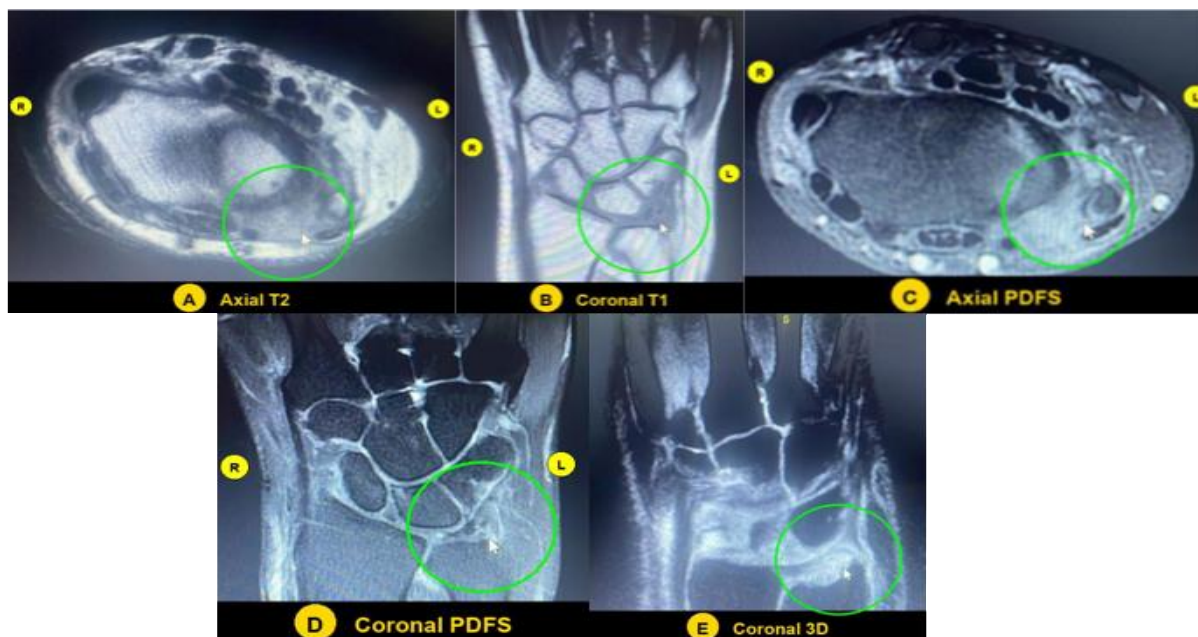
Patient came with complaints of wrist joint pain, decreased range of motion (ROM), and tenderness. Case shows MRI of the left wrist joint. The Coronal T1 (A), Axial T2 (B), Axial / Coronal PDFS (C), and Coronal 3D (D) sequences demonstrate T2 and PDFS hyperintense signals along the TFCC with minimal effusion and adjacent soft tissue edema, suggestive of a TFCC tear. This is also associated with minimal joint effusion in the DRUJ (Distal Radioulnar Joint).
